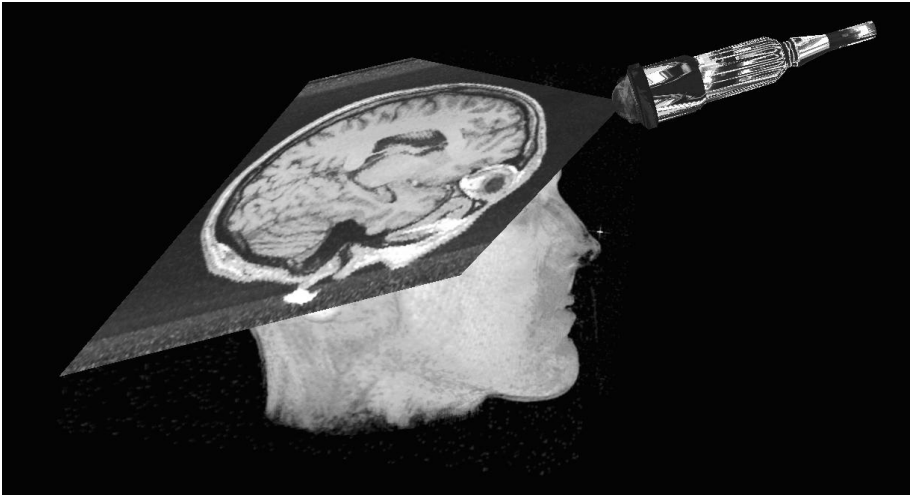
Exploring MRI data of a head with the virtual examination probe. The current slice truncates the virtual model of the head, which is computed from the original data by thresholding.
